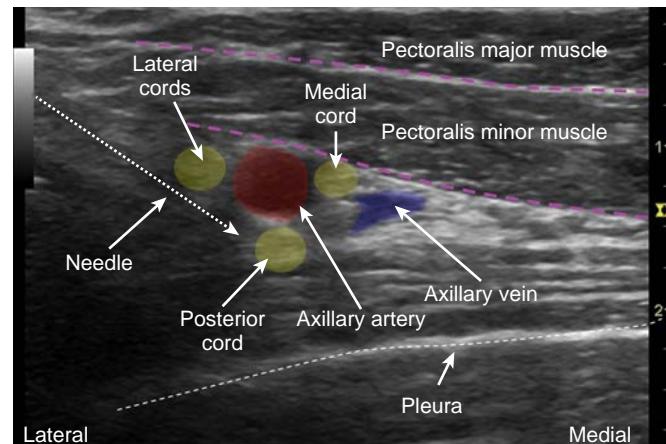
Ultrasound infraclavicular block imaging by paracoracoid approach.
